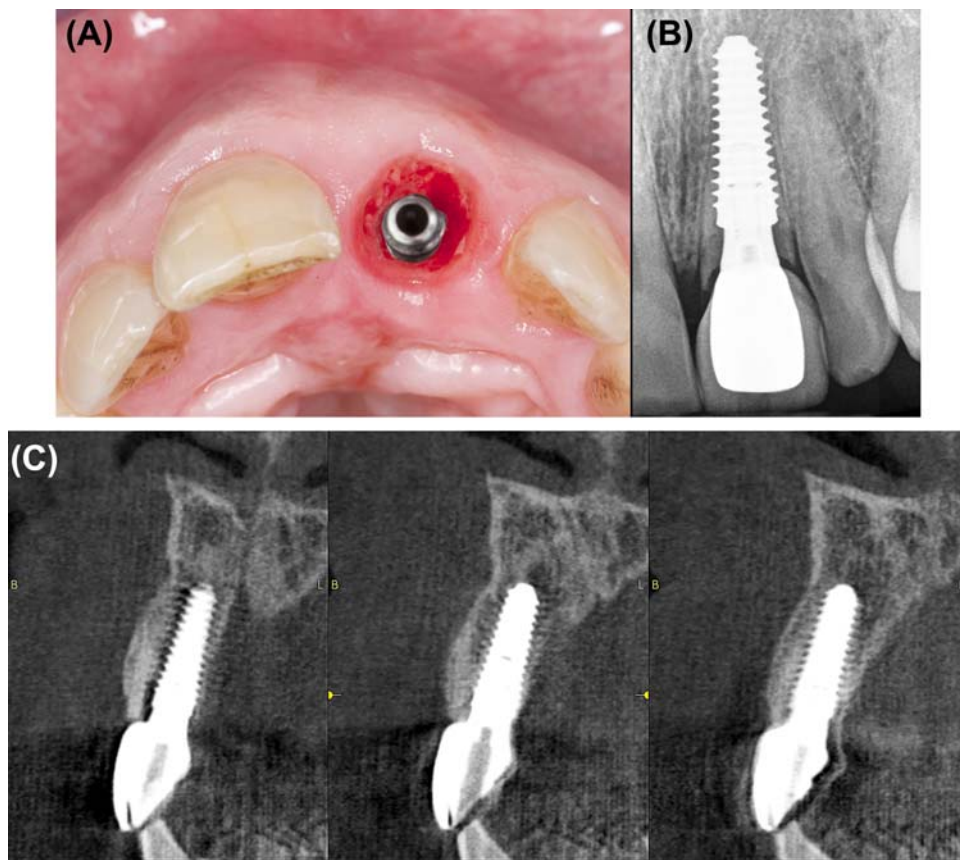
A 3-year follow-up immediate implant at socket-shield site 21. Note the bulk of tissue facial to the implant. (c): CBCT scan demonstrates the hard tissue facial to the implant
